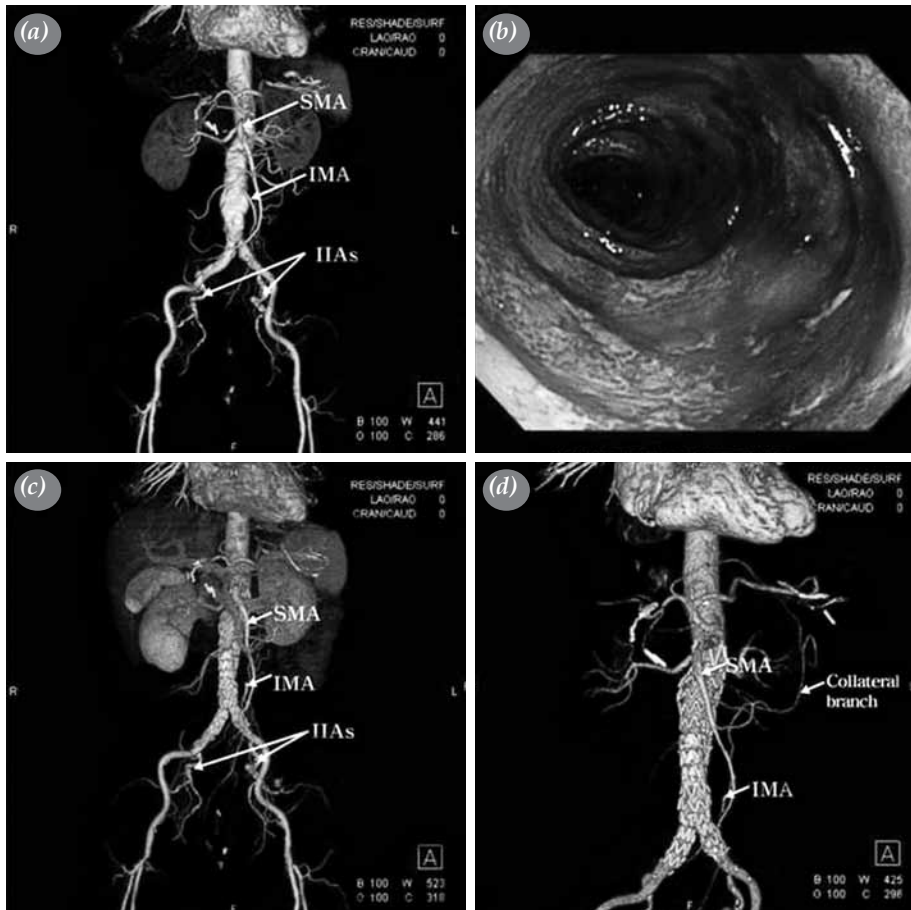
(a) A 4.7 cm fusiform abdominal aneurysm in the axial plane was seen in the superior mesenteric artery on preoperative computed tomography angiography. Both internal iliac arteries and the distal part of the inferior mesenteric artery were patent. (b) Sigmoidoscopic images of ischemic colitis on postoperative Day 1. A diffusely ischemic mucosal injury in the sigmoid colon was seen at 60 cm from the anal verge to 3 cm distally. (c) Follow-up computed tomography angiography on postoperative day 1. The superior mesenteric artery, both internal iliac arteries and the distal part of the inferior mesenteric artery were patent; however, the proximal part of the latter and collateral circulation were not detected. (d) Follow-up computed tomography angiography on postoperative Day 12. The collateral vessel from the superior mesenteric artery to the distal inferior mesenteric artery was able to be well-visualized.
